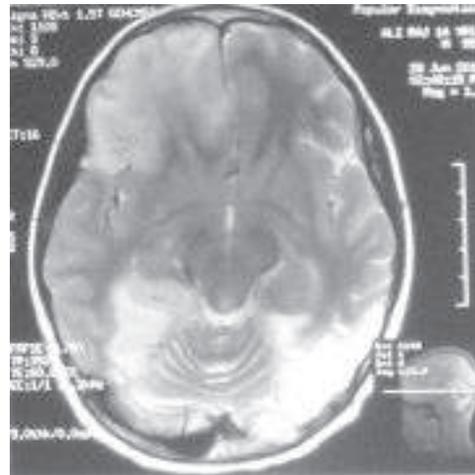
T_1 weighted MRI shows bilateral cerebral ischemic changes of different ages/right sided encephalitis with chronic ischemic changes in left occipital region.
